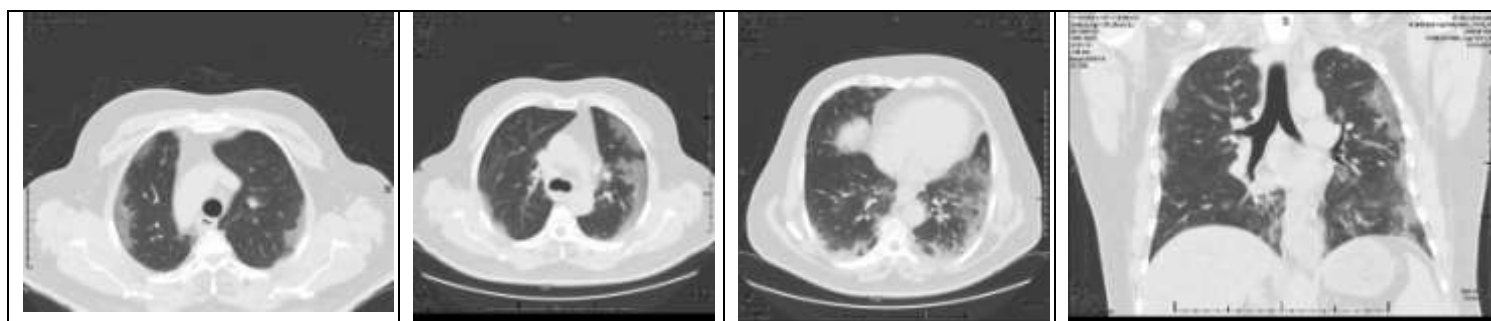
HRCT chest done on 31/10/2020 selected axial images lung window upper, middle and lower lung zones A, B, C, coronal D revealed multifocal areas of ground glass veiling more affecting the left lower lobe showing peripheral subpleural distribution, more along the lung base, normal lung volume.
